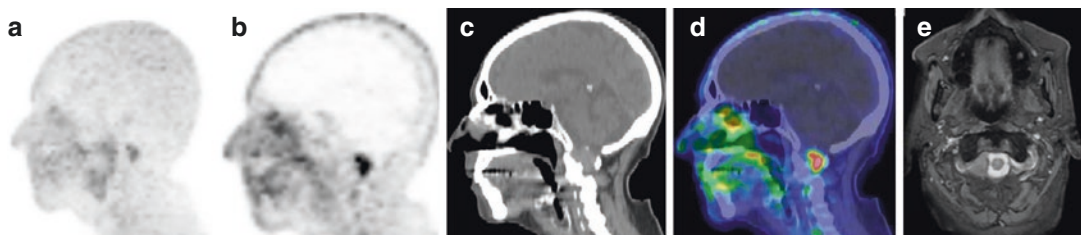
A 64-year-old patient examined by means of ^{64}Cu -PSMA PET/CT for restaging prostate cancer, 2 years after radical prostatectomy. Intense ^{64}Cu -PSMA uptake is documented in the neck, as evident in PET 3D maximum intensity projection (a) and in sagittal PET view (b).
